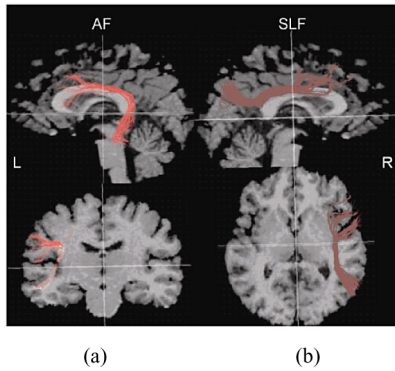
3-D rendering of two major fiber tracts in the brain of a control subject. Fiber tracts derived from deterministic fiber tracking are displayed in the same space as high-resolution T1-weighted MR image volumes. The upper row shows sagittal views whereas the lower row shows coronal and axial views, respectively, for improved spatial orientation. The arcuate fasciculus (a) (on the left, rendered in red) connects cortical language areas while the superior longitudinal fasciculus (b) (SLF, on the right, rendered in brown) connects cortical areas responsible for selection and retrieval of spatial information.
